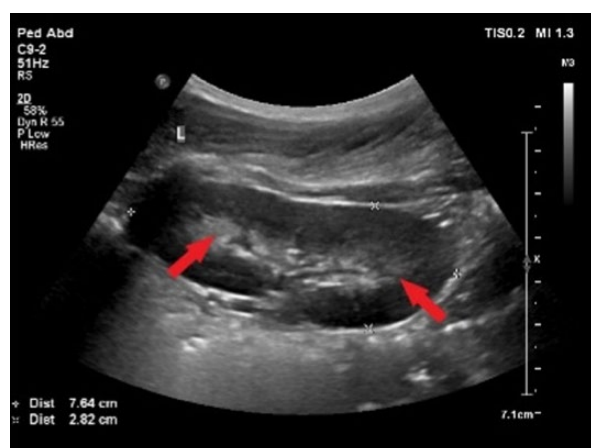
Ultrasound of the patient's left kidney. Note increased echogenicity of the renal pyramids – arrows (Department of Paediatric Radiology, Medical University of Lublin)
